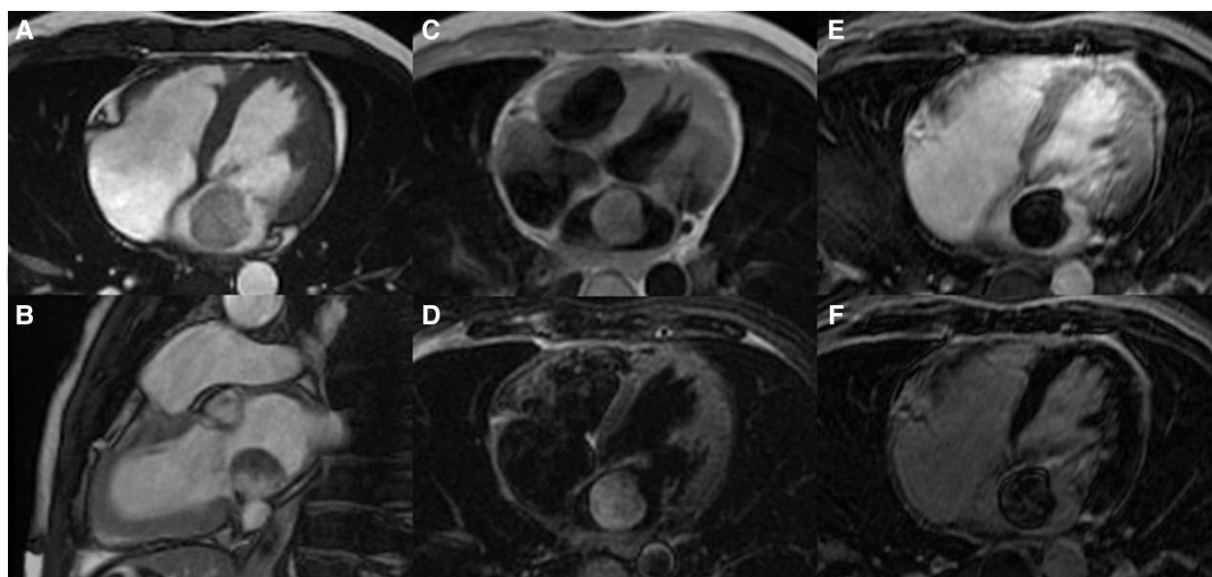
Cardiac magnetic resonance characterization of the mass, showing heterogeneity in most images due to its heterogeneous nature: iso-intense and heterogeneous mass in cine steady-state free-precession (SSFP) images (A and B); iso-intense in T1-weighted images (C); hyper-intense and heterogeneous in T2-weighted images (D); hypo-intense signal in early gadolinium enhancement images (E); heterogeneously enhanced in late gadolinium enhancement images (F).
